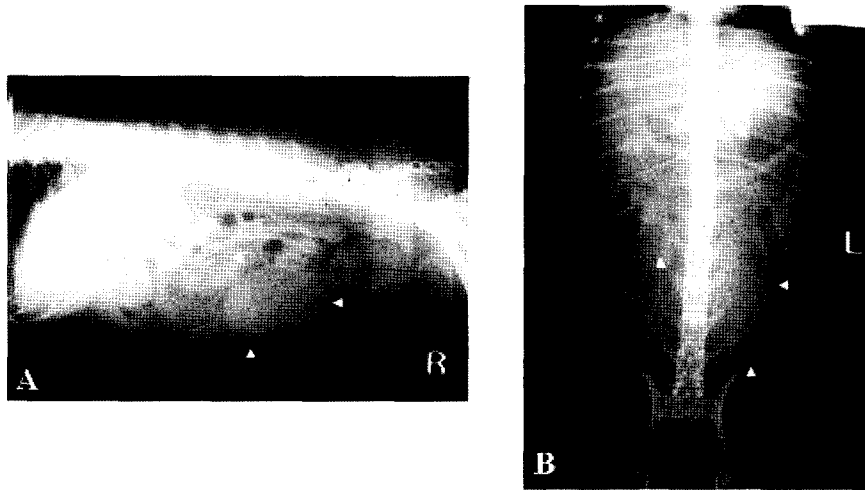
Radiographic appearance of retained surgical gauze in case 1. Lateral (A) and ventrodorsal (B) radiographs in which a focal, well-circumscribed mass with soft tissue opacity was visible in the ventral part of the abdomen. The margin was described by arrowhead.
